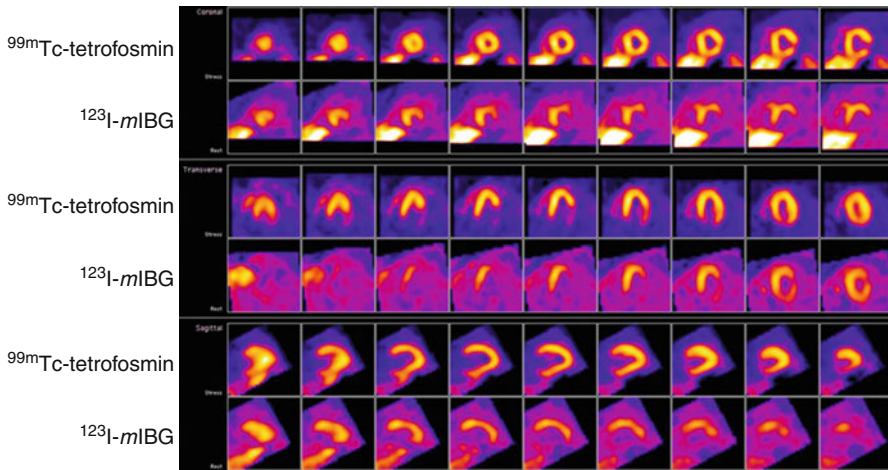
Aligned ^{99m}Tc -tetrofosmin MPI and $[^{123}\text{I}]$ -MIBG SPECT images from a 42-year-old male with history of lateral wall myocardial infarction. *Top* two rows represent reoriented short-axis images, followed by vertical and horizontal long-axis views. There is a small perfusion defect at the base of the lateral wall, corresponding to the known infarct. There is a much larger innervation defect, including both the region of the lateral infarct and almost the entire inferior wall. This pattern of innervation-perfusion mismatch is associated with an increased risk for ventricular arrhythmias
